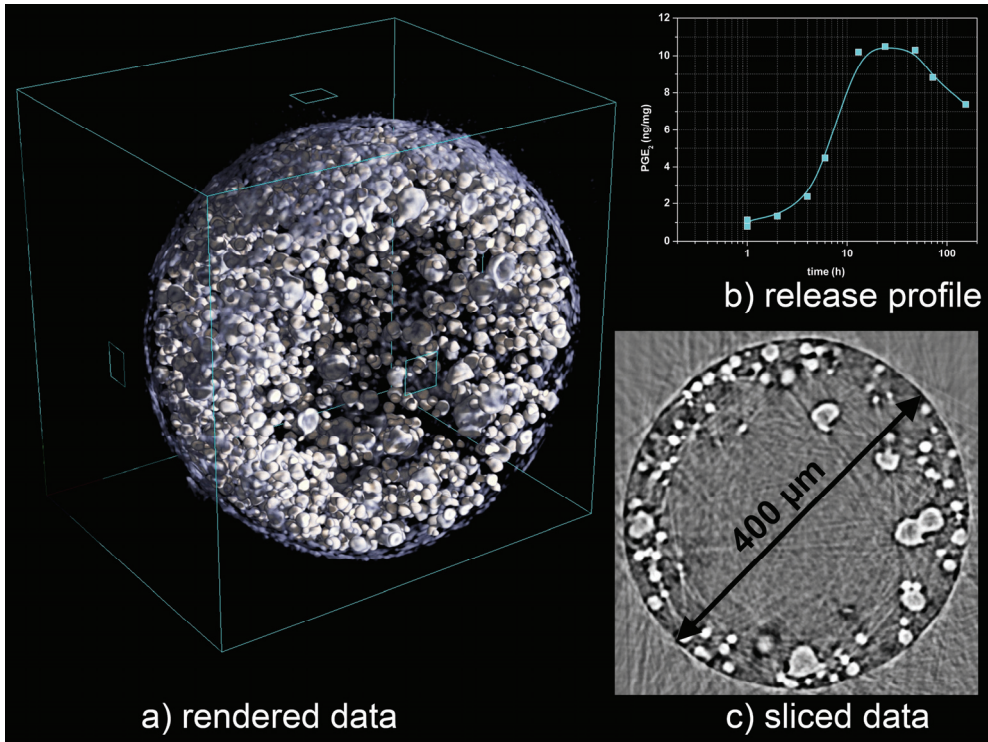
PGE₂-loaded PLGA microspheres: a) rendered SR- μ CT data, b) release profile and c) sliced SR- μ CT data.
